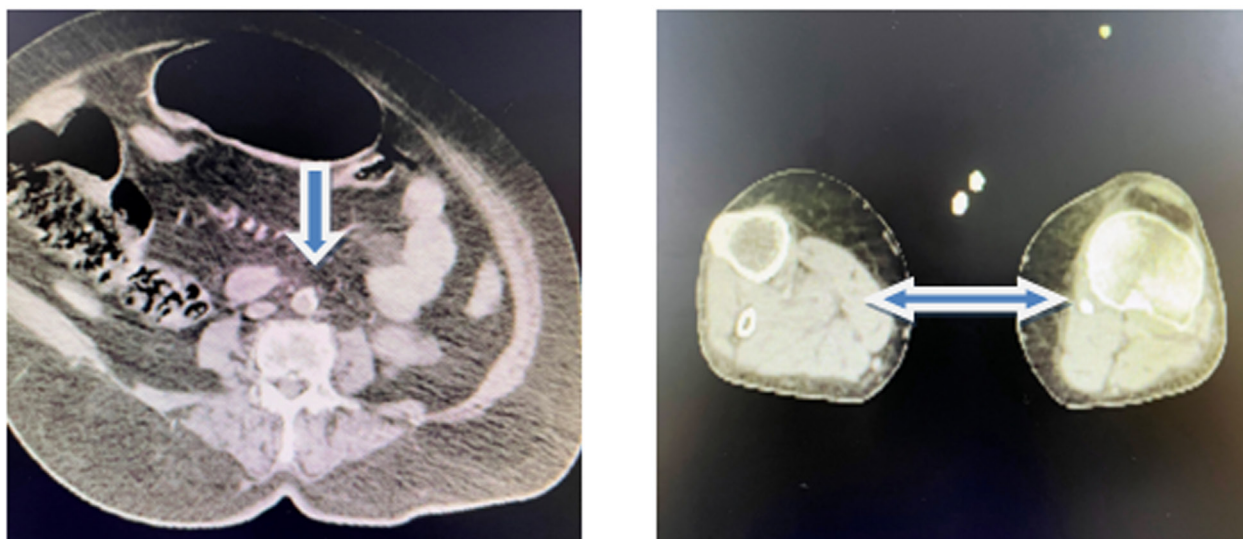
Embolism seen at the level of the abdominal aorta and the right lower extremity in the computed tomography angiography image
